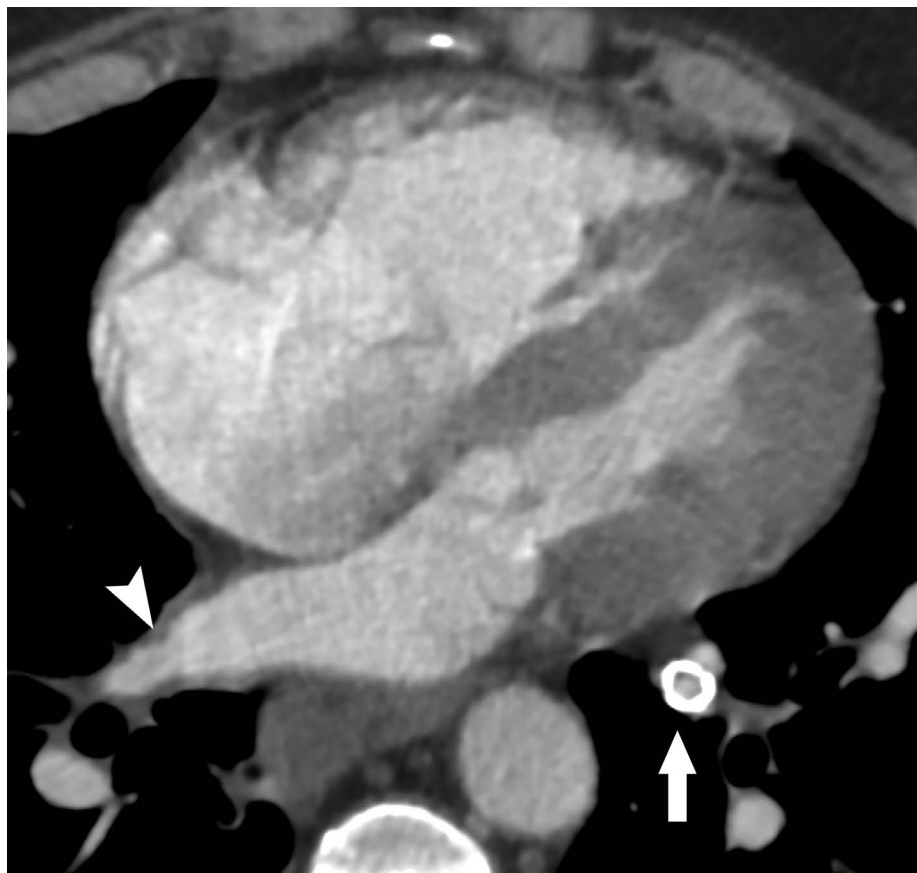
Contrast-enhanced chest computed tomography image shows mild stenosis of the right inferior pulmonary vein (arrowhead) and stent in a left inferior pulmonary vein branch (arrow).
